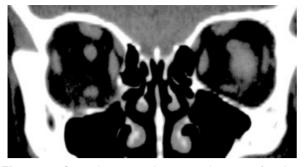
Coronal computed tomography scan of patient with right-sided orbital floor fracture showing some rounding of the inferior rectus muscle. Rounding in this case was not significant (height-to-width ratio <1). Minimal soft tissue herniation into the maxillary sinus is seen. This patient did not have surgery and did not develop enophthalmos.
